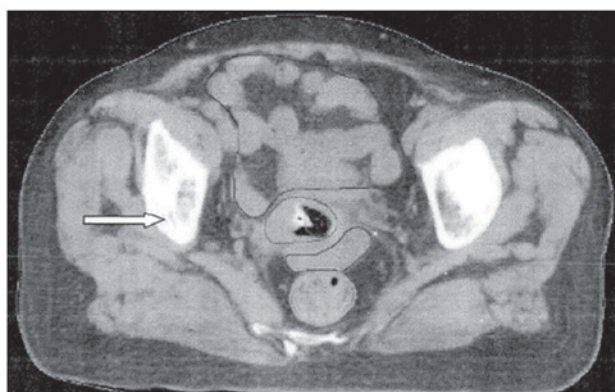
CT images of the visible cervical markers (white arrow).
